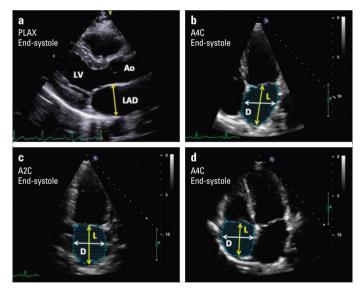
(a) Measurement of the left atrial diameter from the parasternal long-axis view at end-systole. Measurement is done from trailing-edge-to-leading-edge from the posterior aortic wall to the posterior aspect of the left atrial wall in a plane parallel to the mitral annulus. (b and c) Measurement of left atrial volume using Simpson's biplane method from the apical four-chamber (A4C) and apical twochamber (A2C) views at ventricular end-systole (maximum LA size). The LA length (L) is measured perpendicular from the mid-point of the segment that unifies the hinge points of the mitral leaflets, up to the ceiling of the LA. The LA minor dimension (d) is represented by a white line from the lateral wall to the interatrial septum. Care wastaken to exclude the pulmonary veins while tracing the LA. (d) Measurement of the right atrial (RA) area end-systole from the parasternal fourchamber view. The right atrial major dimension (L) is represented by the yellow line from the tricuspid annulus plane center to the superior RA wall, and the RA minor dimension (d) is represented by the white line from the anterolateral wall to the interatrial septum.
